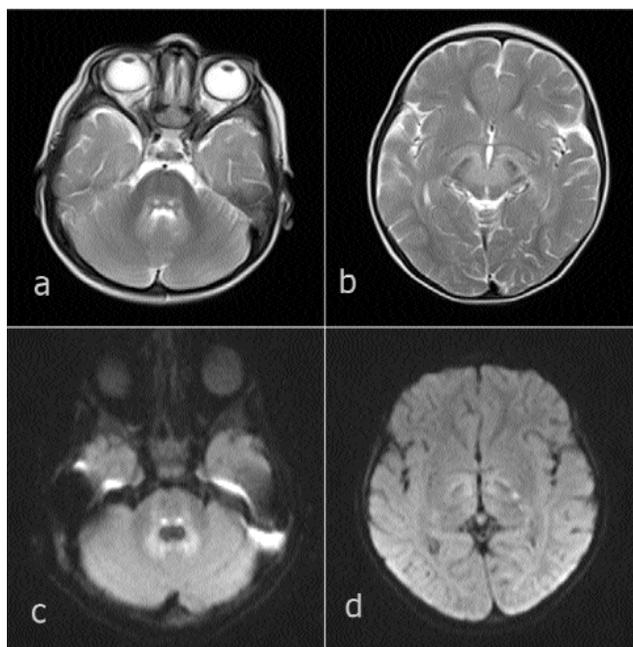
The axial T2-weighted MR image (a) shows signal increases in bilateral dentate nuclei, pons posterior and the axial T2-weighted MR image (b) shows symmetric signal increases in bilateral cerebral peduncles along with diffusion restrictions in axial DAGs (c, d) passing through these levels.
